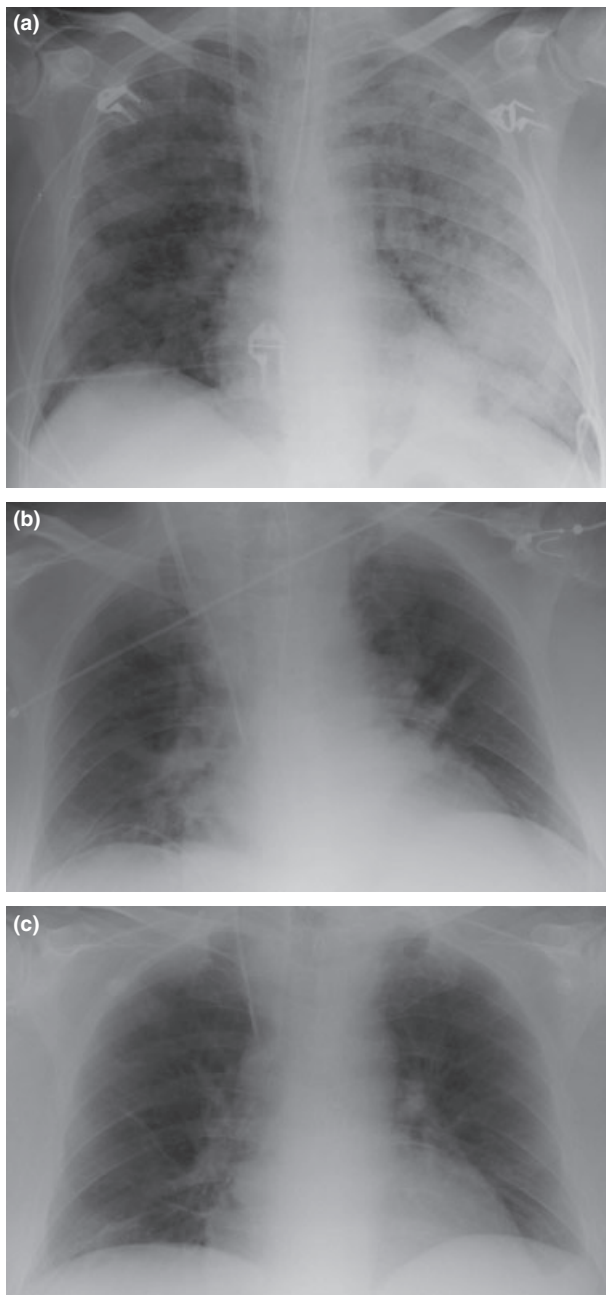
Chest X-ray of patient 2, 2 days before orthotopic liver transplantation (OLT, a), at 1 week (b) and 2 weeks (c) after OLT. Before OLT, the patient had pulmonary infiltrates predominantly on the left side and bilateral pleural effusion. One week later pleural effusion and infiltrates have almost disappeared. Two weeks after transplantation, the patient had chest X-ray without further pathological findings.
